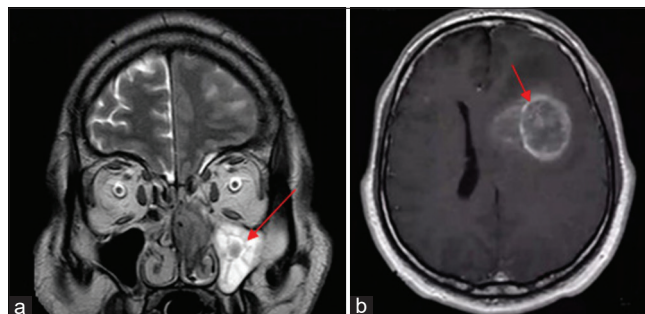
(a) Preoperative coronal T2-weighted magnetic resonance imaging image shows hypointense lesion in maxillary sinus measuring $51 \times 30 \times 14$ mm (red arrow). (b) Axial T1-weighted MRI image shows hypointense lesion in the left frontal lobe measuring $50 \times 45 \times 44$ mm in diameter (red arrow).
